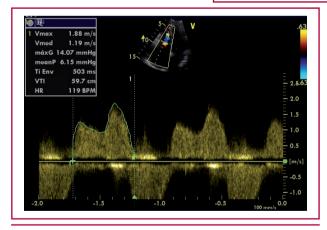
Two-dimensional echocardiography. Four-chamber apical view, spectral Doppler of transtricupid diastolic flow. Notice the significant increase in flow rate and the velocity time integral (VTI).
